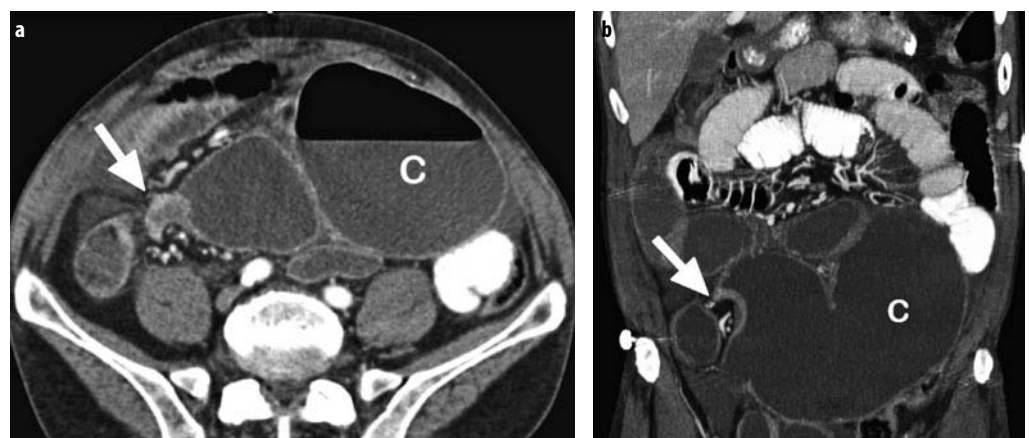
a, b. Cecal volvulus. Transaxial CT (a) and coronal volume-rendered (b) CT demonstrate a markedly dilated cecum (C) in the left side of the pelvis. The arrow points to the area of twist of the ascending colon. Note the dilated small bowel loops due to the proximal colonic obstruction
